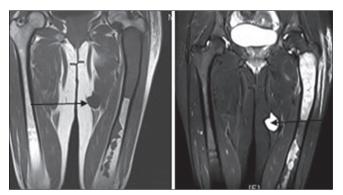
MRI of pelvis showing a well demarcated, intramuscular soft-tissue mass with low signal intensity (SI) on T1-weighted image and a high SI on T2-weighted image consistant with intramuscular myxoma
